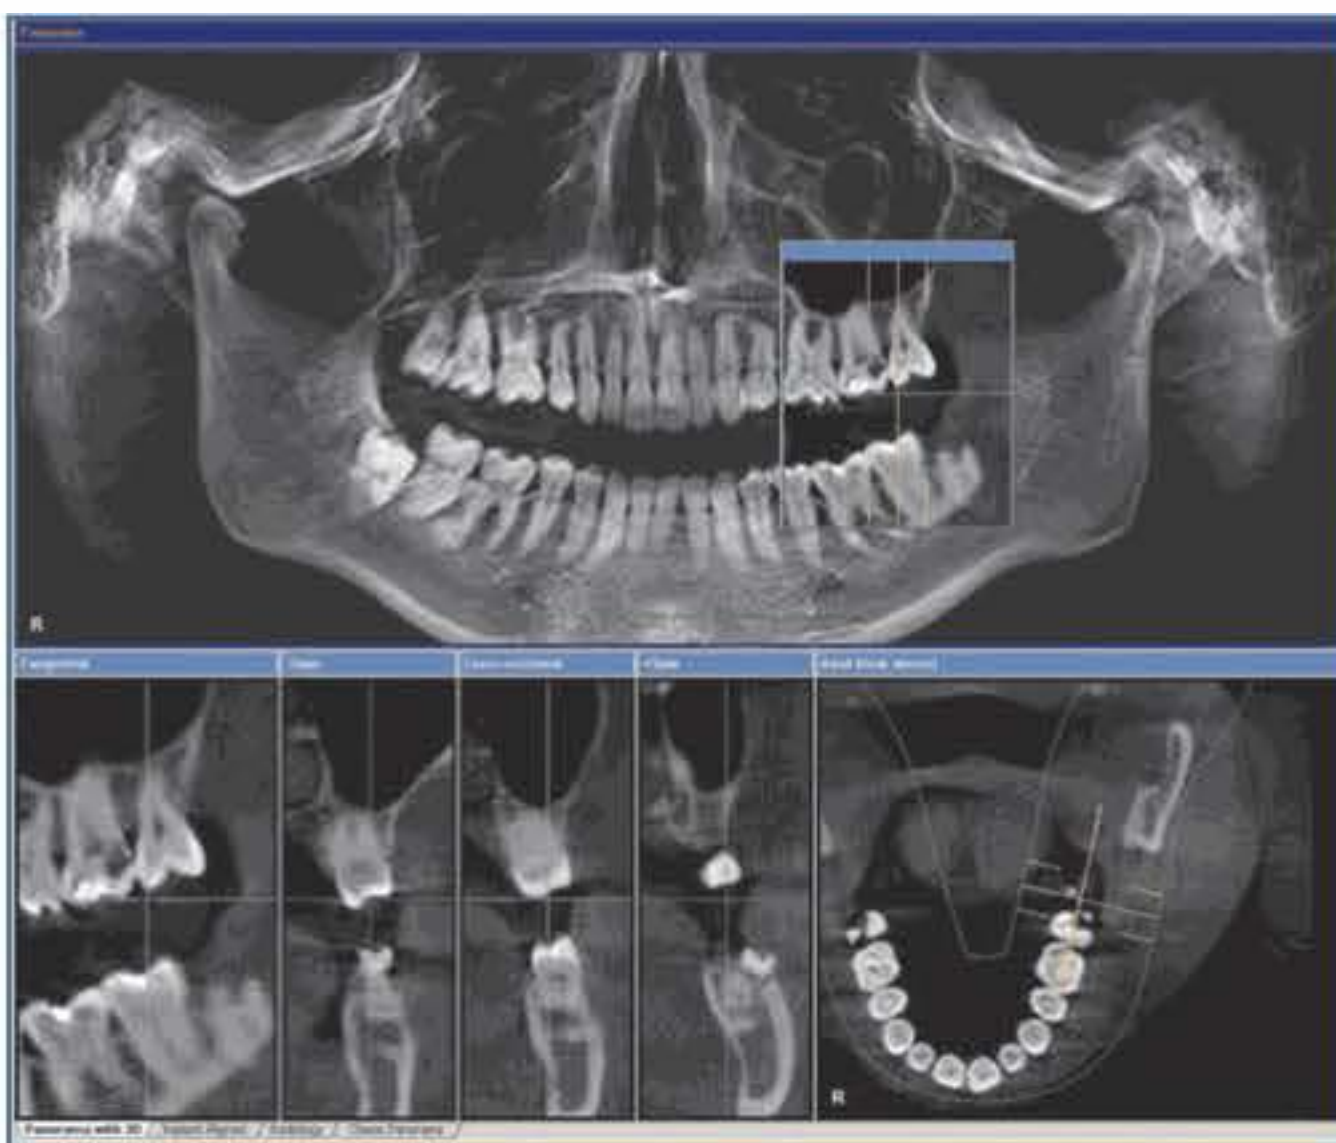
The extent of the radiological translucency of tooth 27 is evident in the panoramic view of the CBCT of the patient in Fig 7-3. In the tangential view, the tooth surface discontinuity can be seen at the bottom left. In addition, the carious lesion probably extends in depth to involve direct pulp contact.
